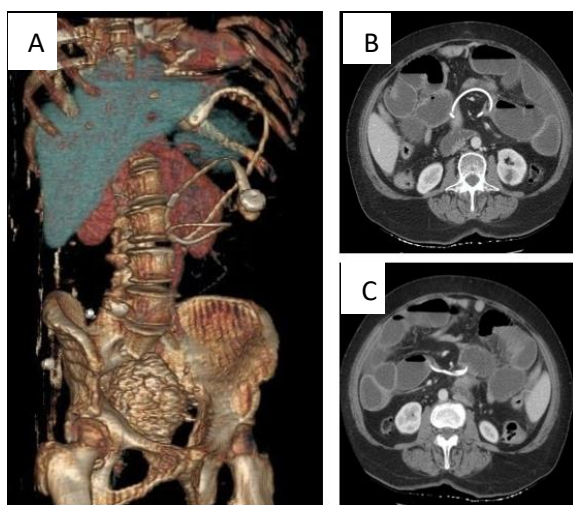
(A-C): Computed tomography scan.
